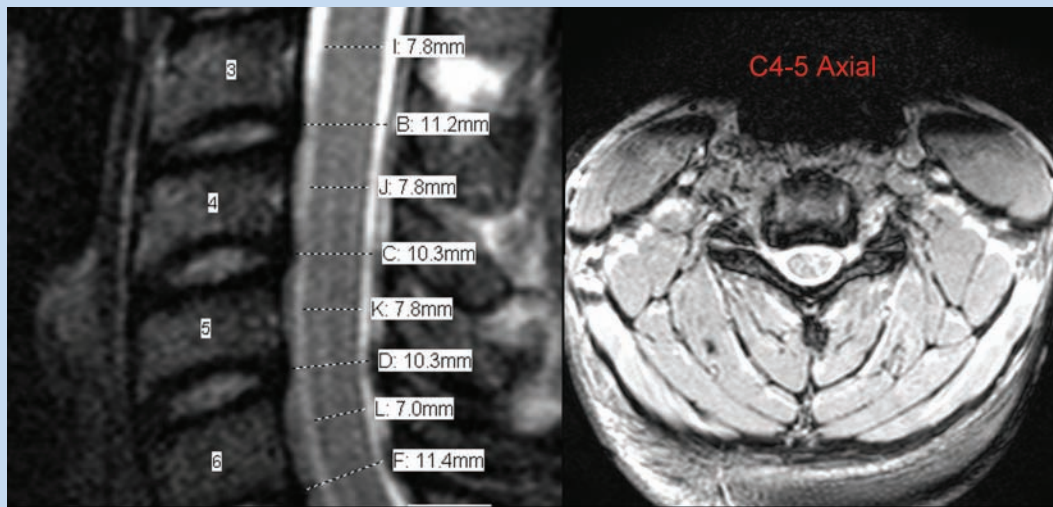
Left, midsagittal view on cervical MRI used to calculate mean subaxial cervical space available for the cord (MSCSAC) index; right, axial view on cervical MRI at C4-5 level demonstrating lack of focal disc pathology or nerve root impingement.
